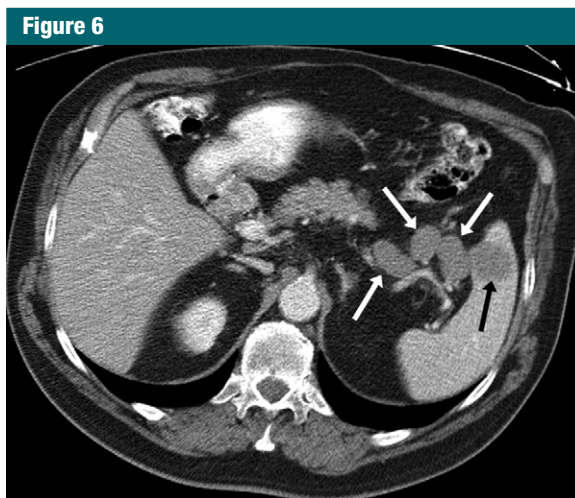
Images in a 78-year-old man who presented with hematuria and no constitutional symptoms or left upper quadrant pain. Axial CT image of abdomen acquired with oral and intravenous contrast material demonstrates splenic mass (black arrow) and perisplenic lymphadenopathy (white arrows), raising concern for lymphoma. This was confirmed at splenectomy.
